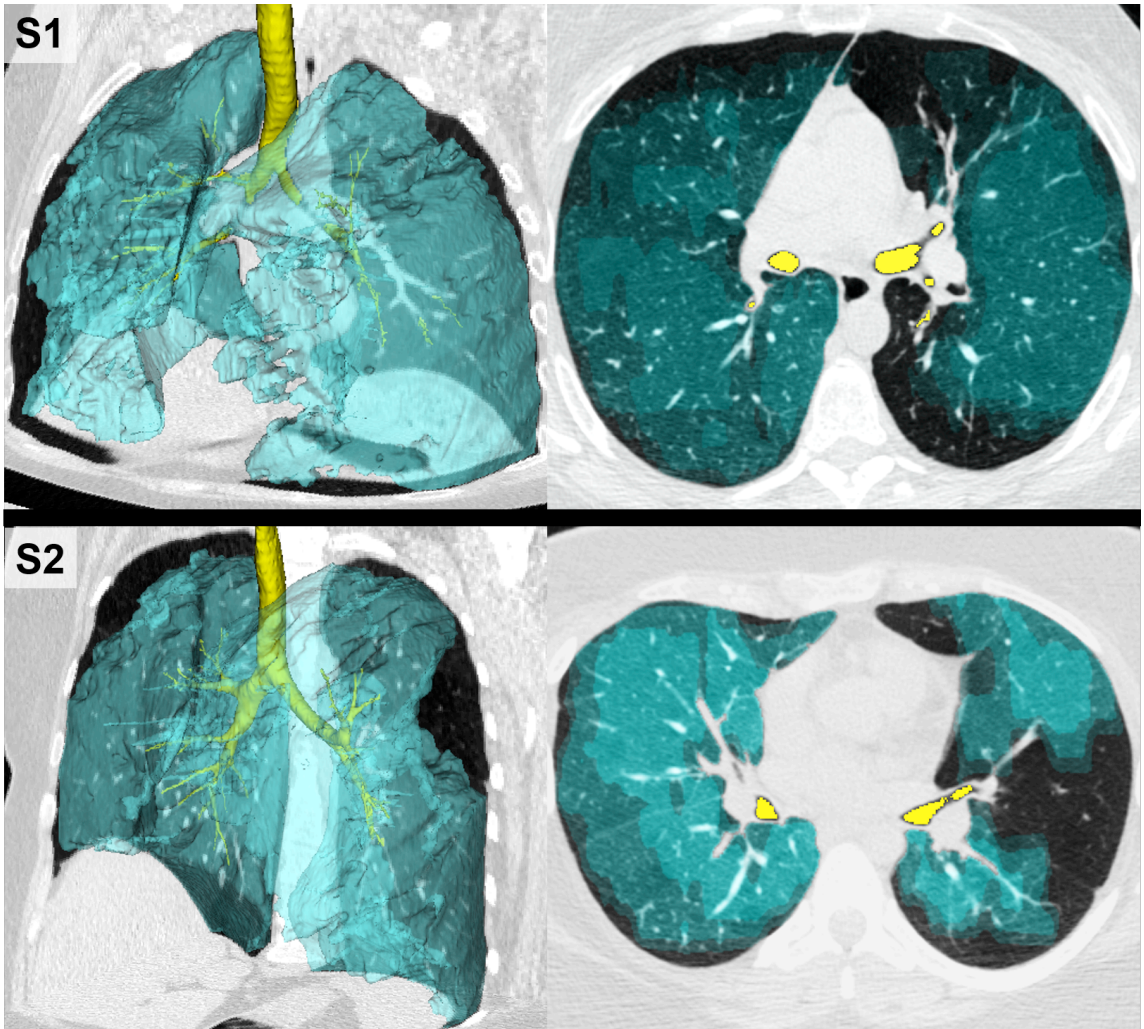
MR and CT Imaging of Lung Structure and Function
